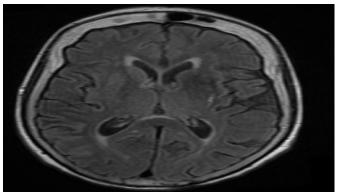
In MRI, hypointensity in FLAIR series in the same area
